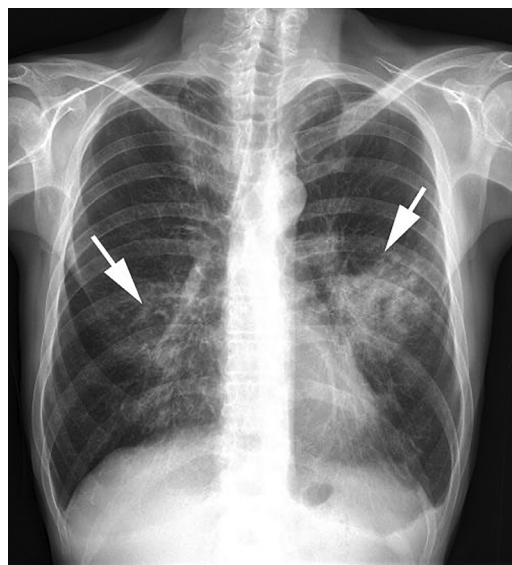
Haemophilus influenzae* pneumonia. (A) A 49-year-old man with fever. Posteroanterior chest radiograph shows bilateral areas of consolidation with ill-defined margins (arrows). A community-acquired *H influenzae* pneumonia was diagnosed.
